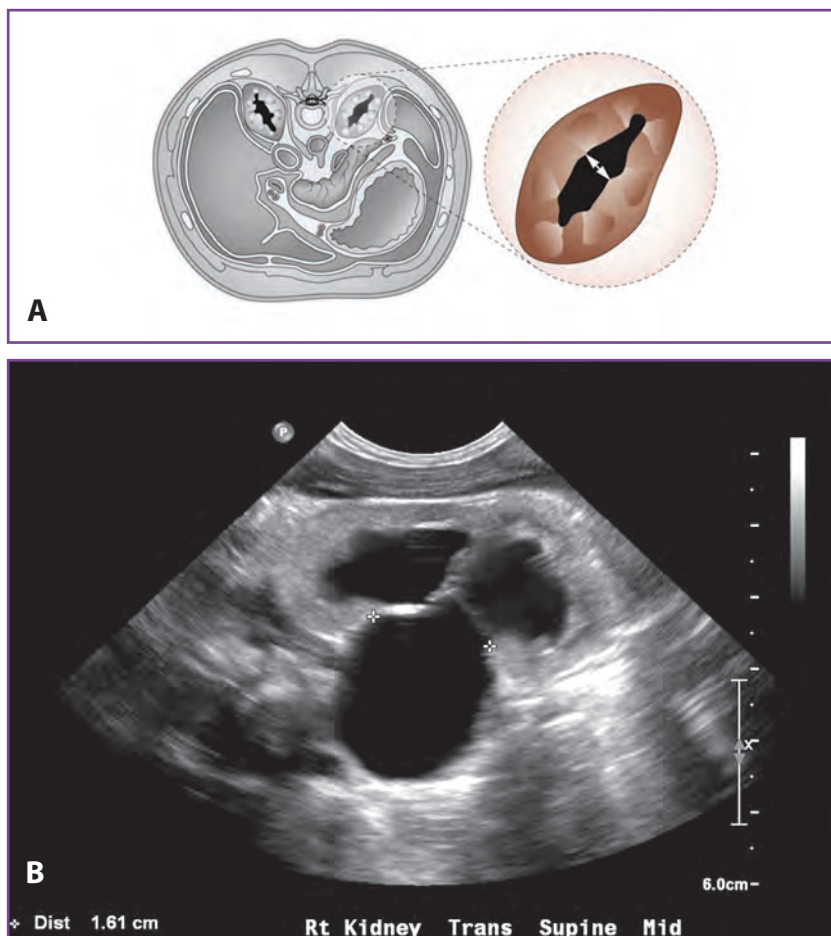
A, The anteroposterior renal pelvic diameter (APRPD), or anterior-posterior diameter, is the maximum anterior-to-posterior diameter of the renal pelvis measured in the transverse plane. The APRPD is frequently measured in the transverse plane at ultrasonography (US). B, Renal US demonstrates an APRPD of 1.61 cm.
